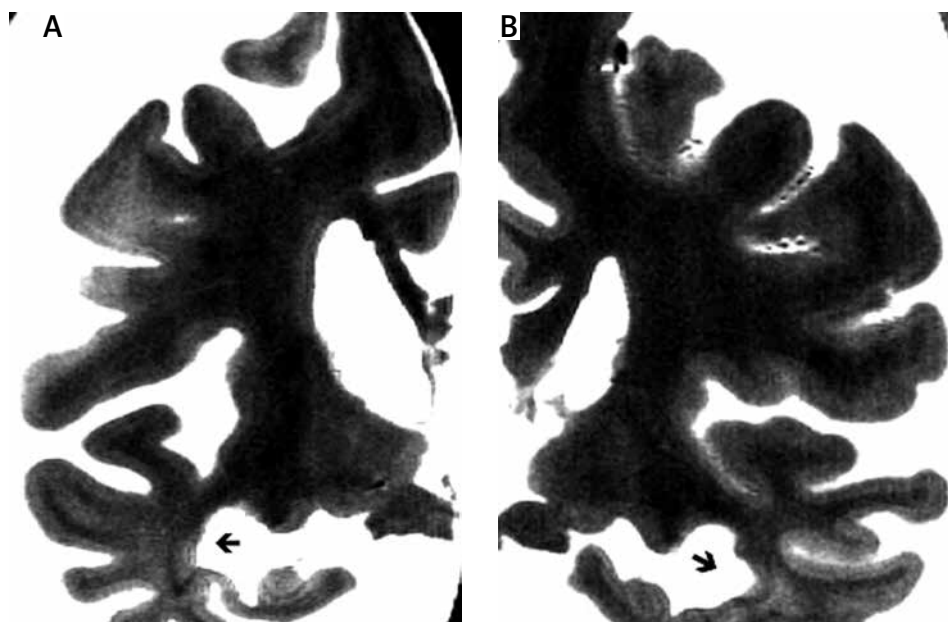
T2 MRI of a central coronal section of a mixed dementia brain showing, in addition to the enlargement of the temporal horn, more selective temporal white matter changes.
